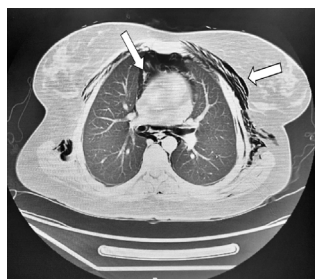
CT-scan chest demonstrating subcutaneous emphysema.
